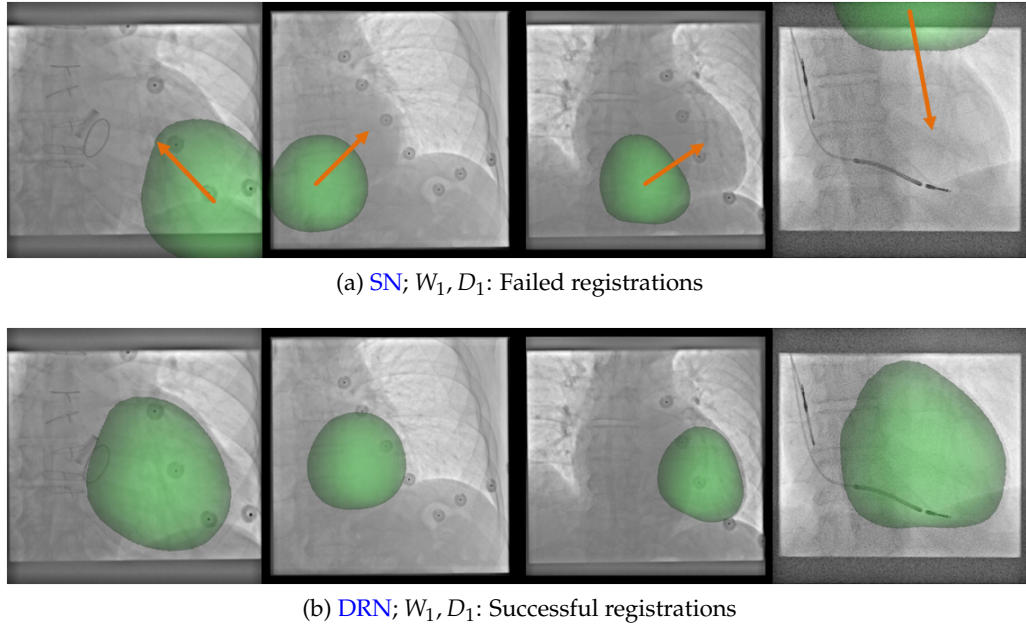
Effects of DR on the target domain (clinical patient X-ray data) on the AP angulation range. Baseline qualitative results with fixed seeds (W_1 and D_1) of the (a) standard (SN) and the (b) domain randomized network (DRN).
